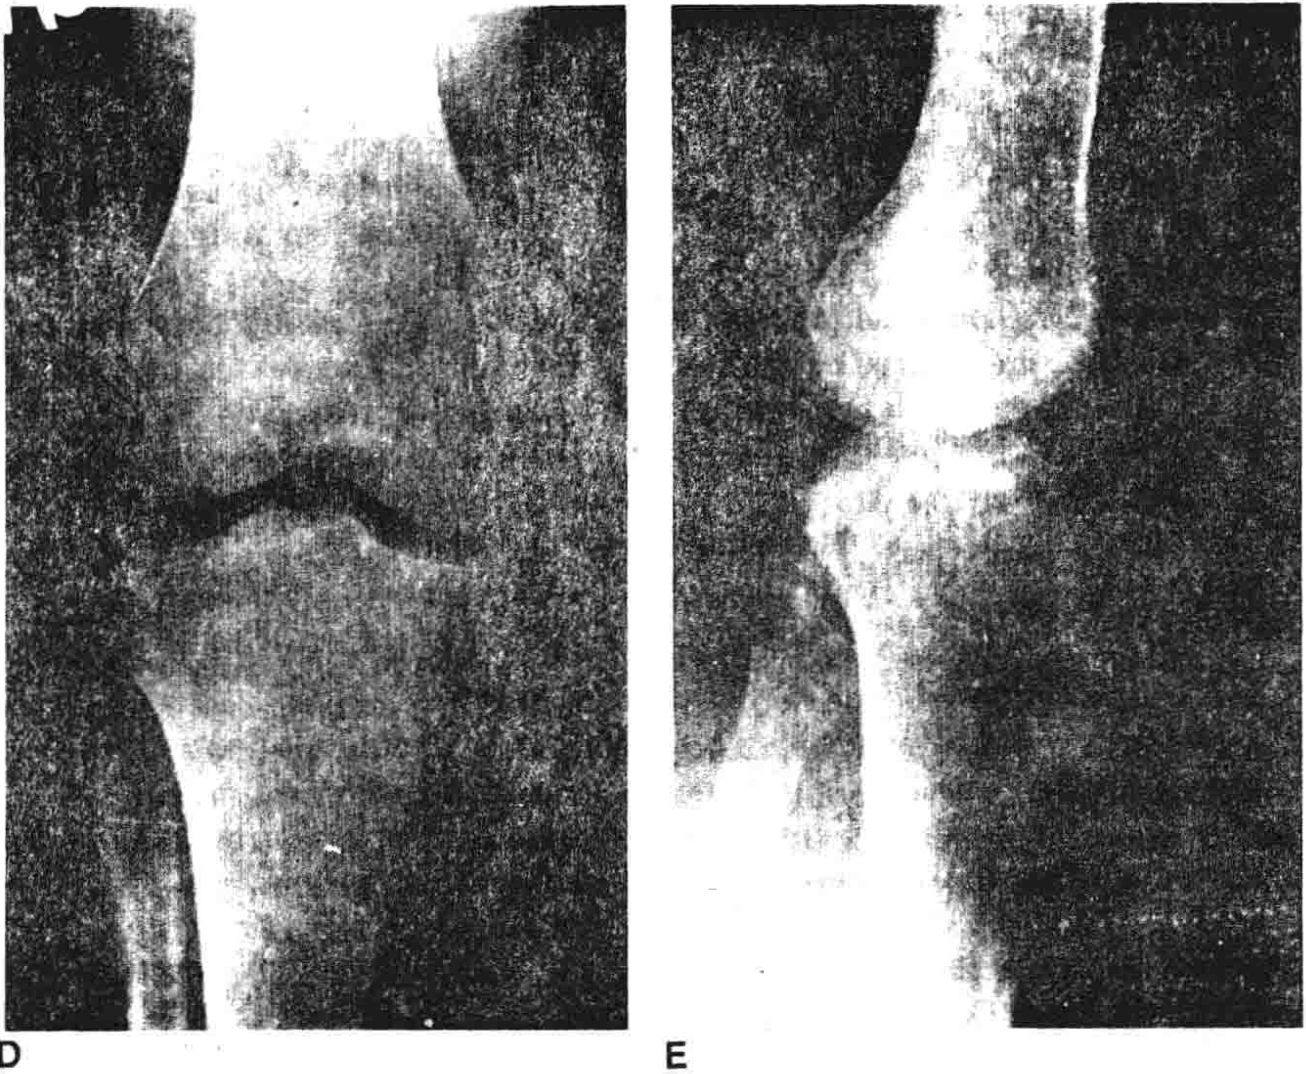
(Continued). (D,E) Anterior-posterior and lateral radiograph (D,E). Radiographs show implant removal and fracture healed.
